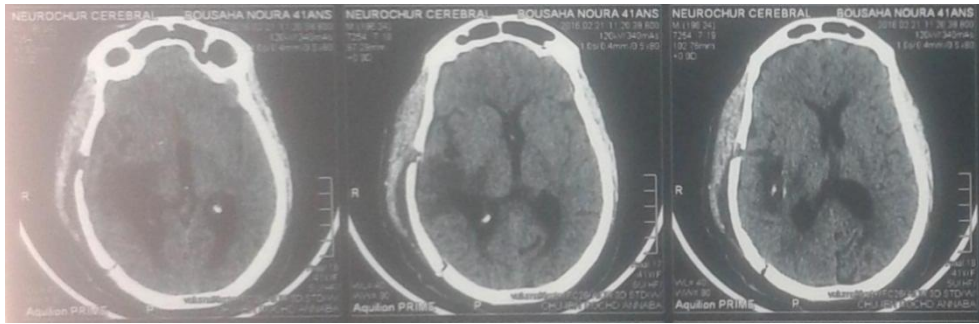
03: Post-operative cerebral CT scan; total excision of hydatid cyst.
